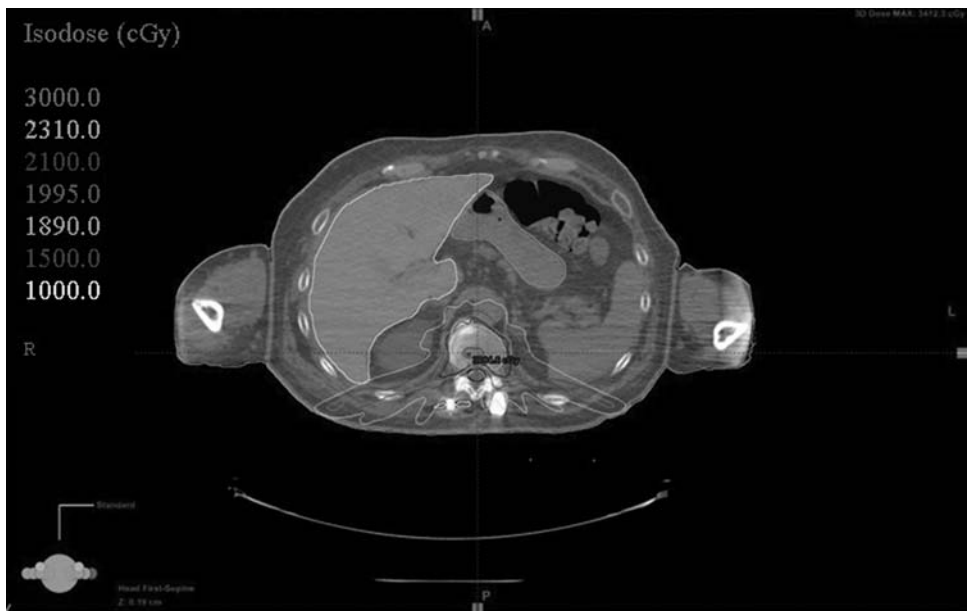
An axial CT image demonstrating the conformal SBRT isodose lines around a T11 vertebral body metastasis in a patient with a paraspinal carcinoma status post prior external beam radiotherapy. The plan was developed with intensity modulated radiation therapy to a dose of 2100 cGy in 3 fractions. The spinal cord is outlined in black. The planning target volume is in the light gray color wash.
